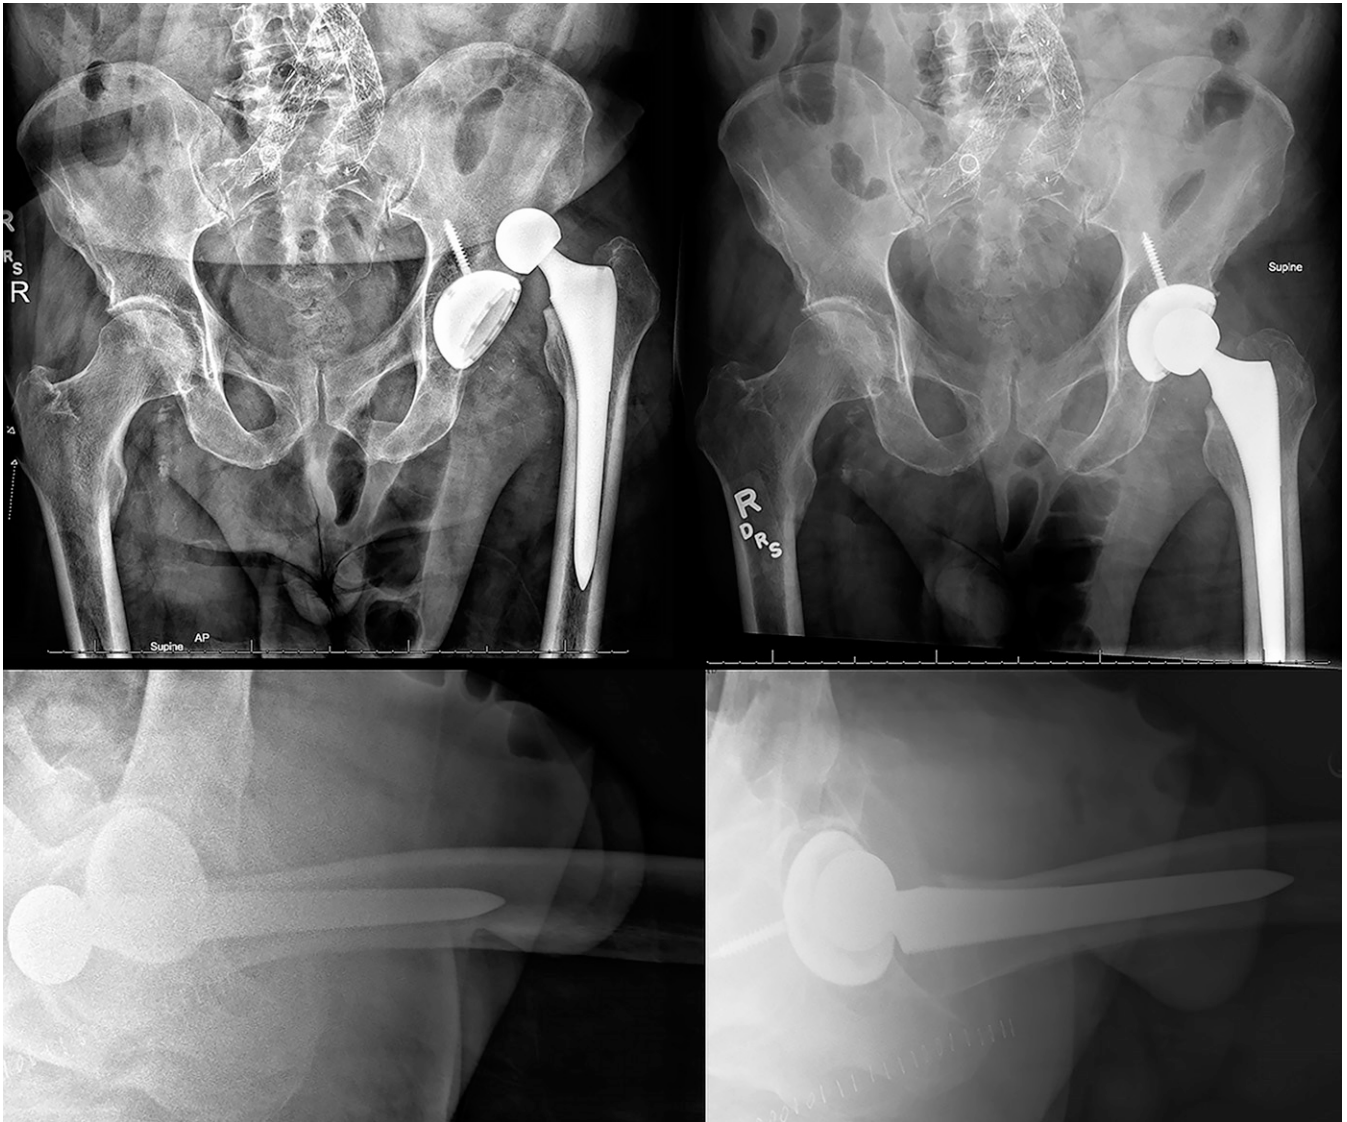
Anteroposterior (top) and lateral (bottom) radiographs of a 79-year-old man with a dislocation after a primary total hip arthroplasty (left, top and bottom), which was treated successfully with closed reduction (right, top and bottom).
